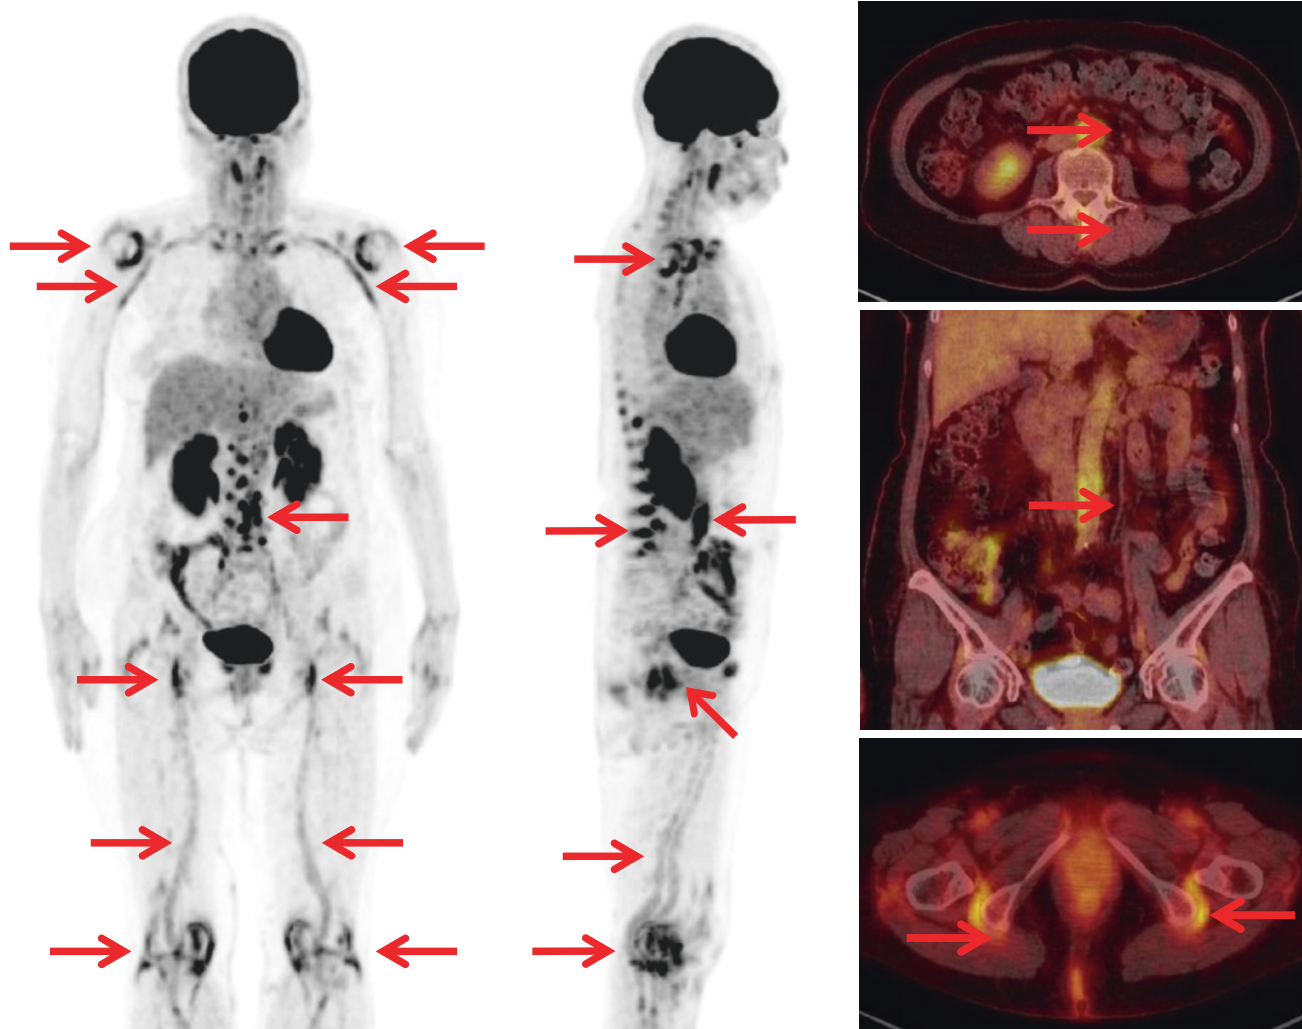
^{18}F -FDG-PET/CT images before therapy
